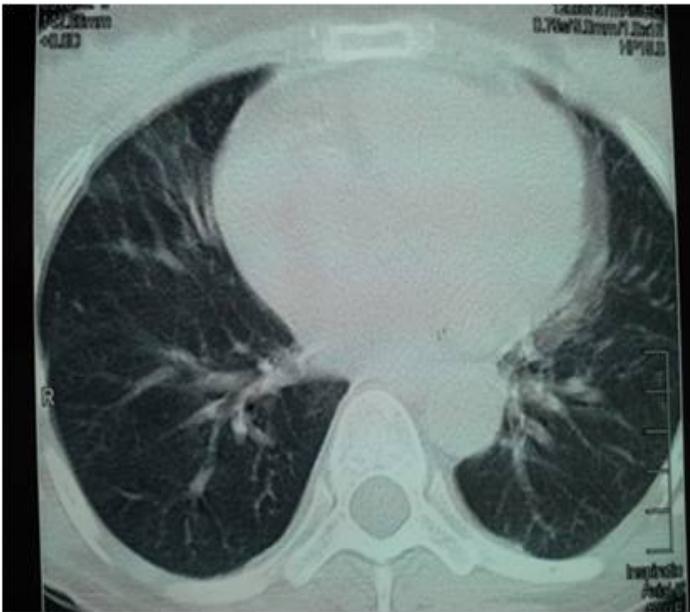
HRCT of the chest showing normal lung parenchyma
